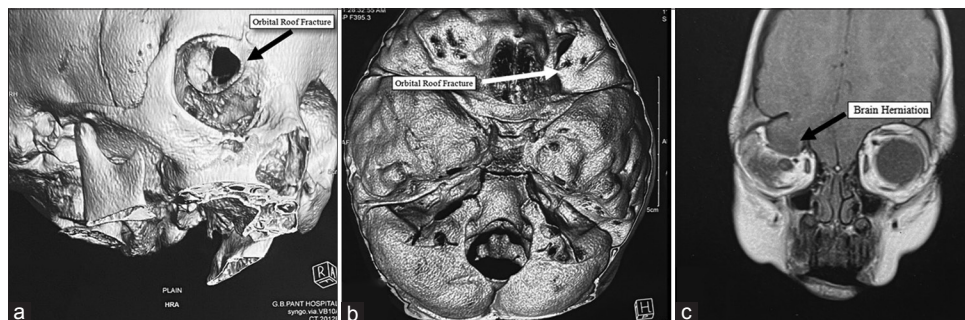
(a) Fracture in the roof of the orbital cavity. (b) Fracture in the floor of cranial fossa. (c) Magnetic resonance imaging revealing brain herniation and dural tear
